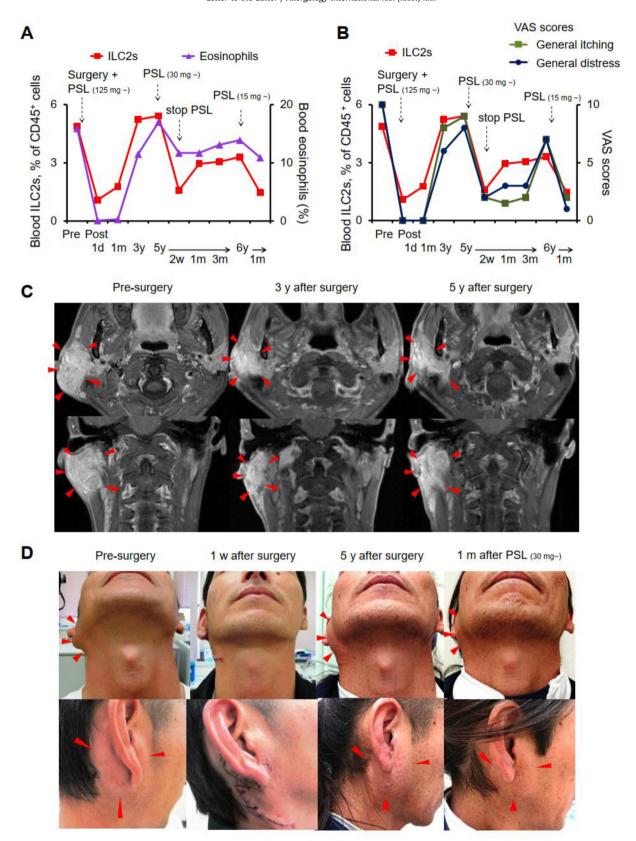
Changes in the prevalence of blood ILC2s, blood eosinophilia, clinical symptoms, MRI findings, and photographs in a representative severe case of KD before and after surgery and steroid therapy. A, Changes in blood ILC2 prevalence and the percentage of blood eosinophils. PSL, prednisolone; d, day; w, week; m, month; y, year. B, Changes in blood ILC2 prevalence and the visual analog scale (VAS) scores of general itching and distress. C, Changes in axial and coronal MRI (T2-weighted images) showing a mass lesion in the right parotid area (red arrows). D, Changes in swelling of right parotid area (red arrows).
